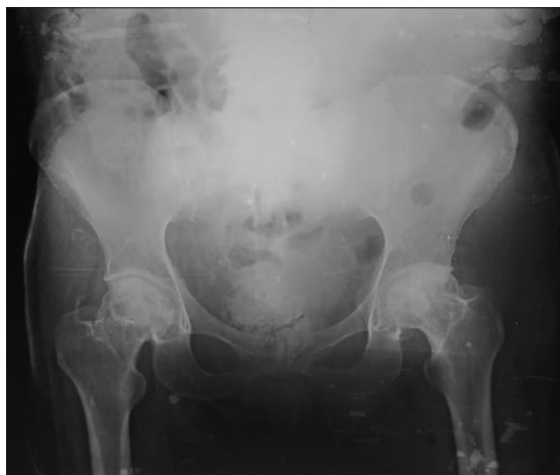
Anteroposterior radiograph revealing bilateral avascular necrosis of the femoral head
